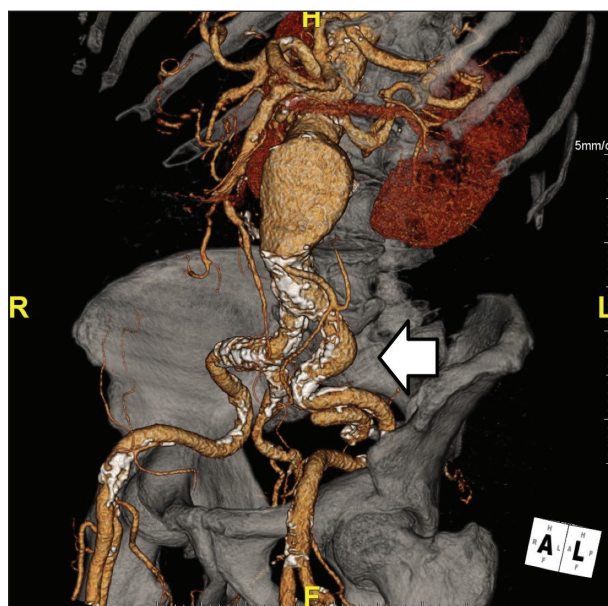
Volume-rendered CT image demonstrating tortuous and calcified iliac arteries.
